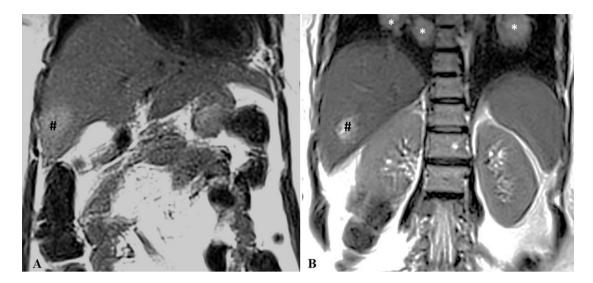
Coronal T2 weighted MRI (A) and (B) showing hyperintense metastatic lesion (#) involving segment six of right lobe and multiple hyperintense nodular lesions (*) in bilateral lower lung fields.
